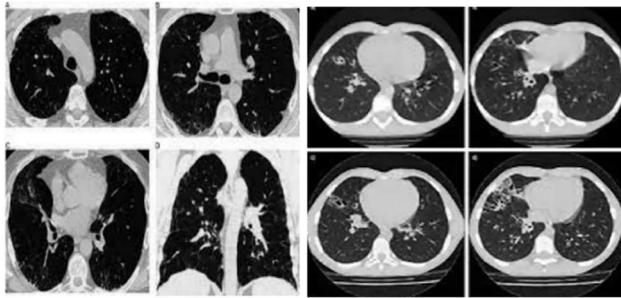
Samples of lungs from HRCT scan
